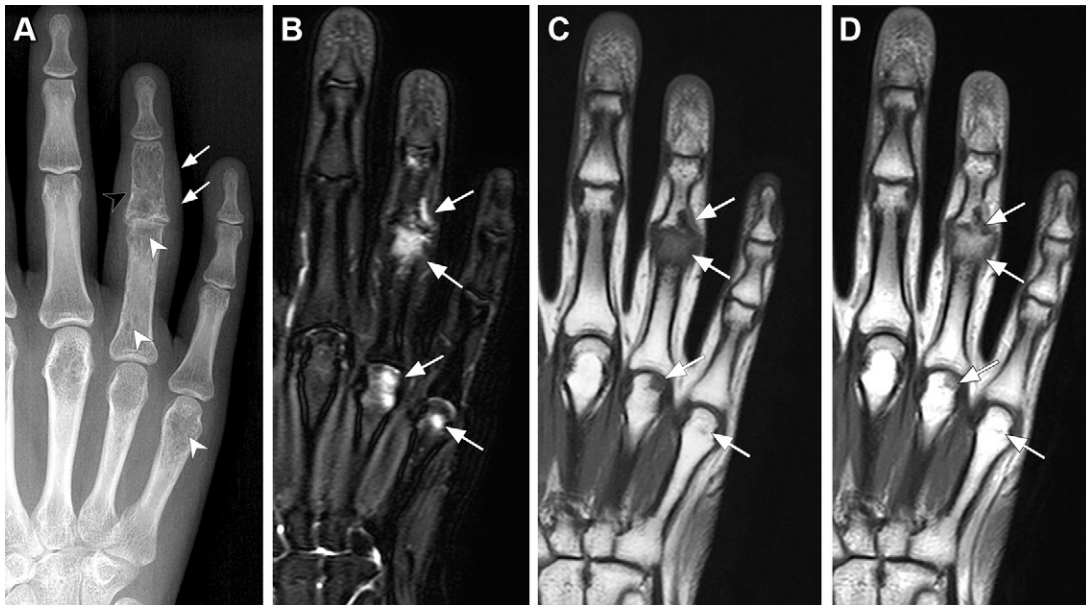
Small bone sarcoidosis in a 17-year-old adolescent girl who presented with swelling of the left fourth finger. (A) Radiograph of the left hand shows soft-tissue swelling (arrows) and a lacelike lytic pattern (black arrowhead) in the middle phalanx of the fourth finger, with multiple well-defined lytic lesions in the phalanges and metacarpal bones (arrowheads). (B–D) MR images obtained after corticosteroid therapy show that the soft-tissue swelling and bone lesions have regressed. Coronal fat-saturated T2-weighted MR image (B) shows residual intramedullary lesions in the phalanges and metacarpal bones (arrows). Coronal precontrast (C) and postcontrast (D) T1-weighted MR images show contrast enhancement in the lesions (arrows).
